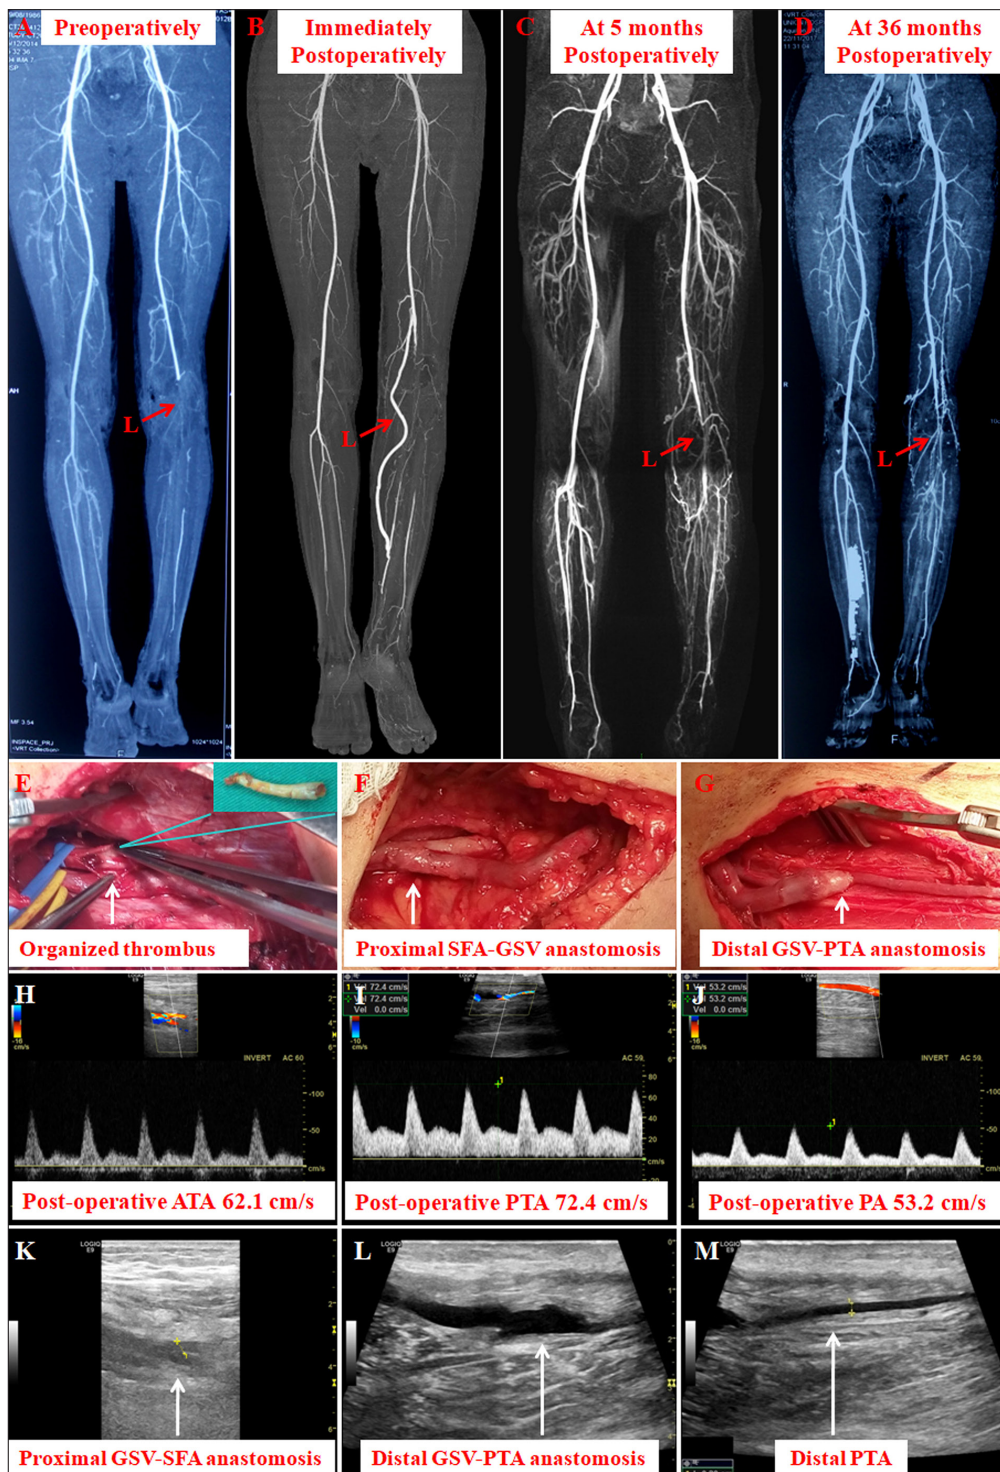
A 28-year-old male cook without a past history of active smoking, complained of rest pain resulting from TAO (A), had underwent a left infrapopliteal bypass with reversed great saphenous vein (B). There was an organized 1-cm thrombus in the tibial-peroneal trunk (E) and a reversed saphenous vein graft was anastomosed end-to-side to superficial femoral artery (F) and posterior tibial artery (G). Postoperative ultrasonography revealed normal arterial flow velocities in calf (H-J) and a patent bypass conduit between superficial femoral artery and posterior tibial artery (K-M). Computed tomography angiography (CTA) on 5 months postoperatively indicated the graft occlusion and collateral vessel development in the affected calf (C). Revision was not attempted, and he continued to have only mild ischemic symptoms at follow-up 36 months postoperatively (D). Abbreviations: GSV, great saphenous vein; SFA, superficial femoral artery; PTA, posterior tibial artery; ATA, anterior tibial artery; PA, peroneal artery.
